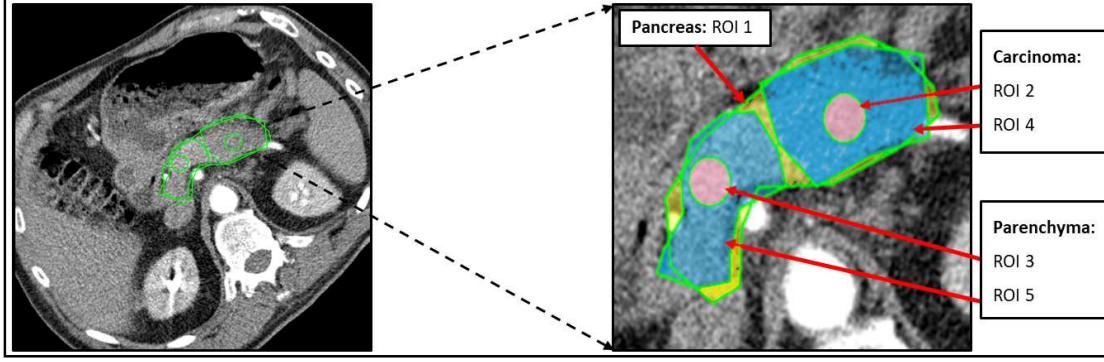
Dynamic CT image from the dynamic CT sequence of a pancreatic adenocarcinoma patient with marked regions of interest (ROIs). The entire pancreatic region is delineated by polygonal ROI1 in yellow, while the carcinoma region is marked by polygonal ROI4 in blue. Within the carcinoma region, a small circular ROI2 in pink is specified to encompass only carcinoma tissue, excluding surrounding tissues or blood vessels. Similarly, the parenchyma region is identified by a polygonal ROI5 in blue, and within it, a small circular ROI3 in pink is placed to encompass solely parenchyma tissue, excluding any other tissues or blood vessels. This detailed annotation provides a comprehensive understanding of the specific areas of interest within the dynamic abdominal CT image
